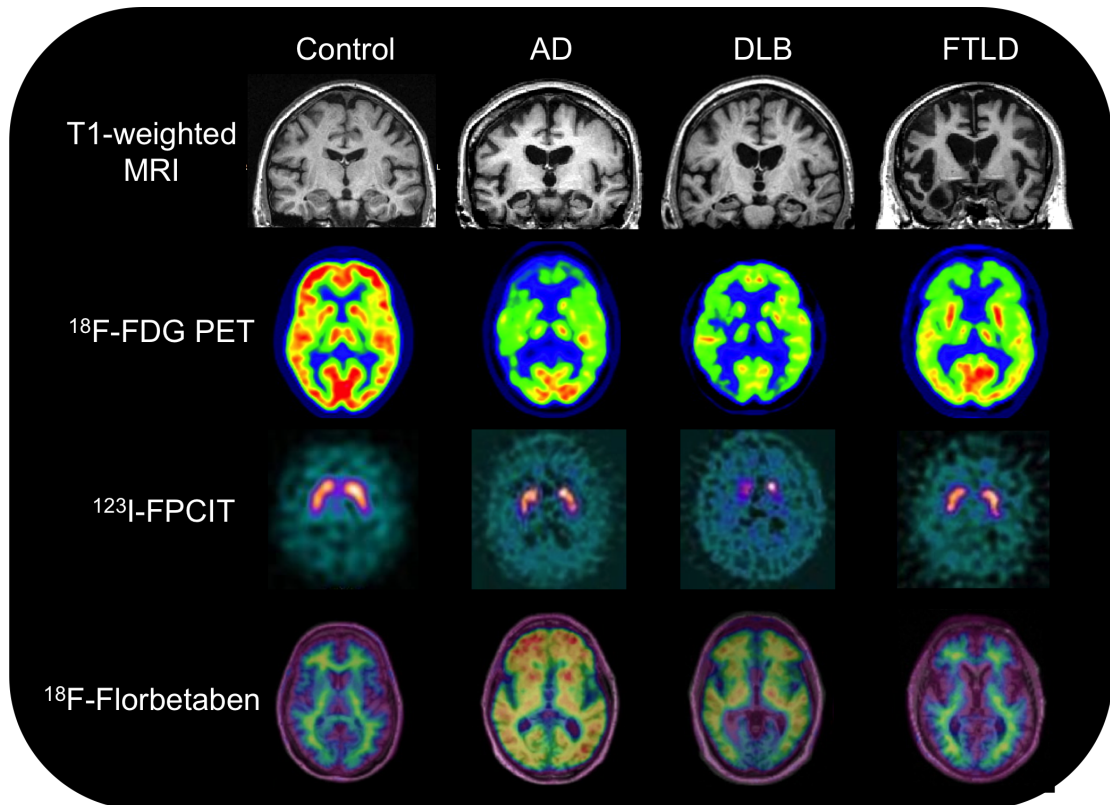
Neuroimaging in the diagnosis of dementia. MRI images are from pathologically confirmed cases. FDG PET images from Koeppe *et al* [78]. FPCIT images from Morgan *et al* [79] with pathological confirmation of Alzheimer's disease and DLB pathology. Only the DLB image is abnormal. Florbetaben images are overlaid on MRI images from Villemagne *et al* [80]. Nonspecific binding is shown in white matter in controls and FTLD, specific binding is shown in cortical areas of Alzheimer's disease and DLB patients.
